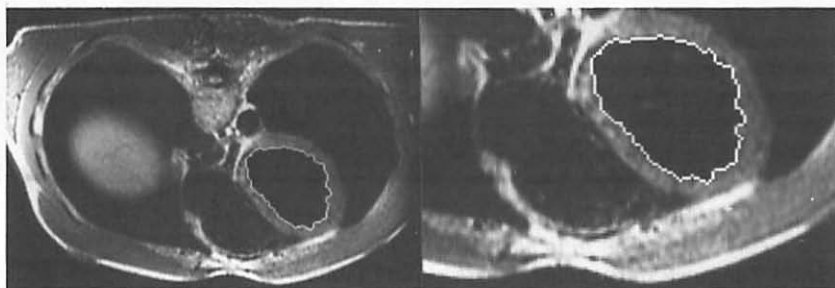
Boundary detection in MRI images. Image on left is a complete 256 X 256 pixel image. Image on right is magnified to emphasize the left ventricle. The boundary contour determined for this section is shown in white.
